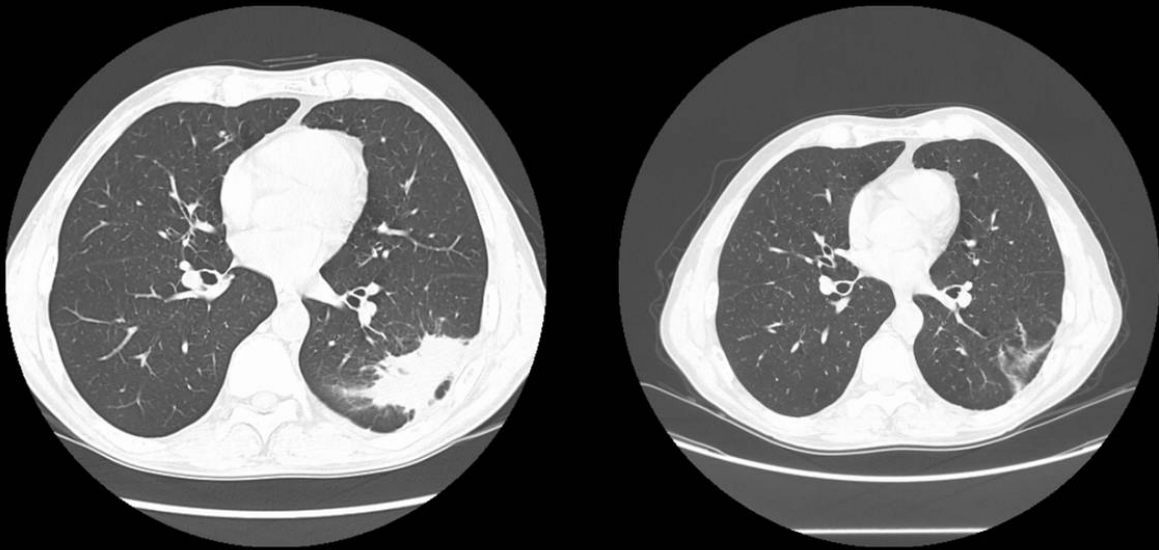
Axial HRCT shows a left lower lobe mass with spiculated margins (a). On biopsy this lesion proved to be organizing pneumonia. Axial HRCT of the same patient after treatment with corticosteroids (b) showing almost complete resolution of the lesion.
